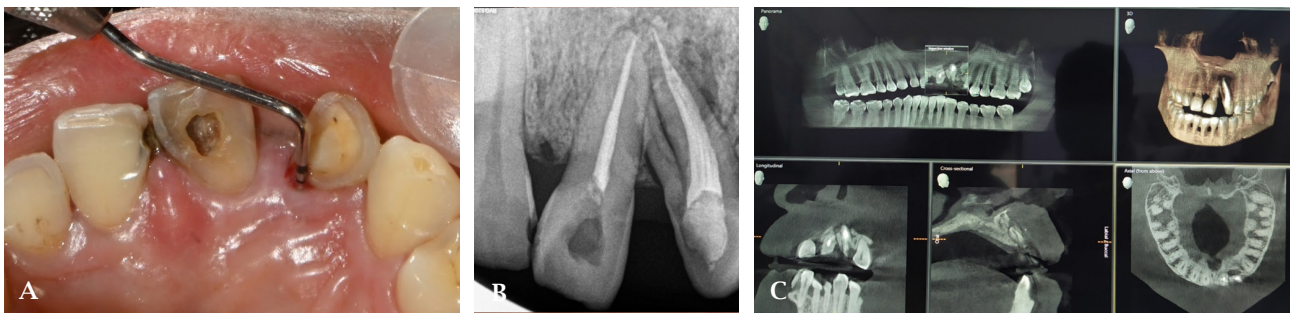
A) Probing pocket depth of 13 mm; B) The IOPA showing bifurcation and periapical radiolucency; C) The CBCT showing small palatal root.
